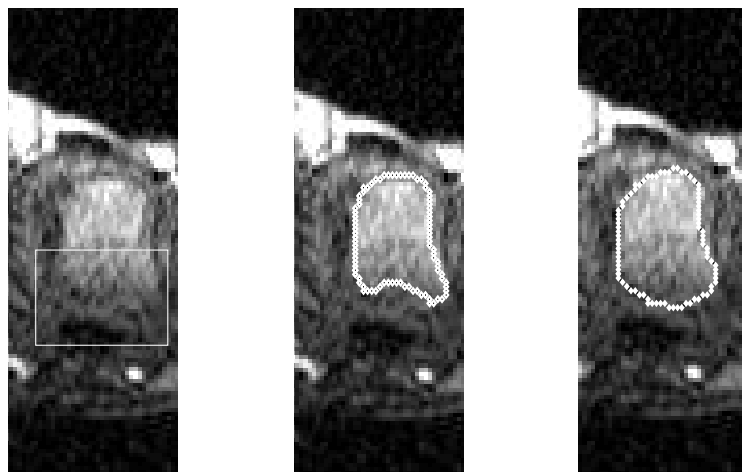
A region from a DCE-MRI study of the MCPJs with a partly ambiguous boundary (left), and two possible GT overlays, highlighted by different human experts (middle, right).
